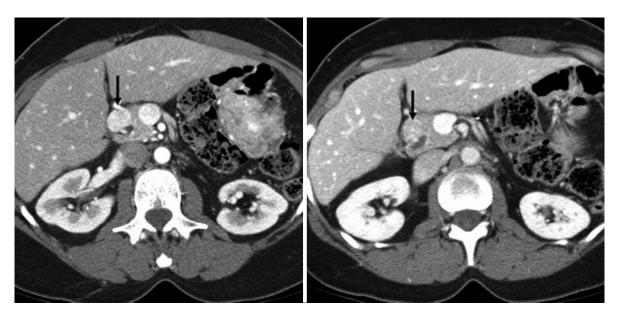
Dual phase MDCT of gastrinoma. Axial CT obtained during the pancreatic phase of enhancement (*left*) shows 1.5 cm hyper-vascular pancreatic isulinoma (*arrow*). During the portal venous phase (*right*) the tumor is iso-attenuating (*arrow*)
